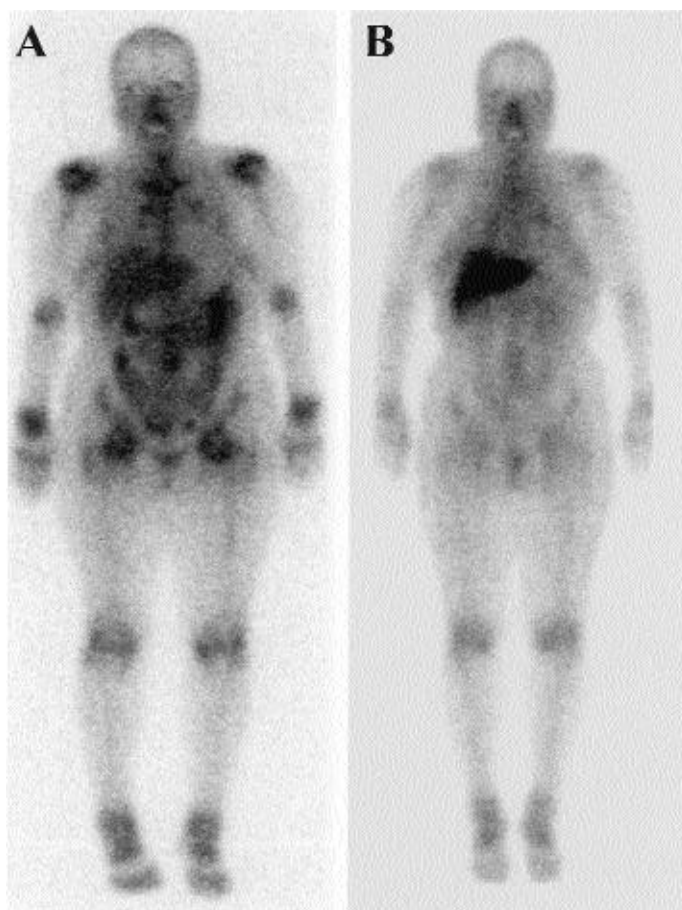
⁶⁷Ga-scintigram in patient 2 before (a) and after the treatment (b).
